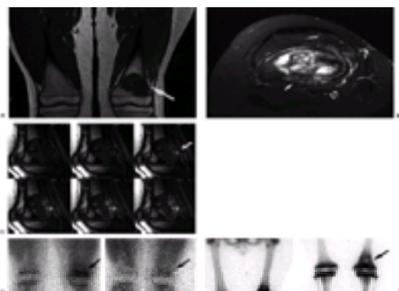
Osteogenic sarcoma in a 14-year-old boy evaluated by MR imaging and scintigraphy. A: Coronal T1-weighted image of the entire femur confirms a tumor with well-defined margins (*arrow*) and no skip metastases. The very low signal intensity area within the tumor corresponds to a cement plug after biopsy. B: Axial fat-suppressed, T2-weighted images show that the tumor extends posteriorly underneath the periosteum (*closed arrow*). The popliteal vessels (*open arrow*) are spared. C: Dynamic fast spoiled gradient echo images, obtained at 3-second intervals, show that the subperiosteal component of the lesion enhances rapidly (*arrow*), indicating persistence of active tumor in this region. This scan was performed after therapy. D: Thallium-201 scan before (*left*) and after (*right*) therapy shows that the intense radiotracer uptake in the tumor (*arrow*) in the initial study decreases markedly after therapy. E: Tc-99m methylene diphosphonate (MDP) scan after therapy shows that there is increased radiotracer uptake in the tumor (*arrow*). There is no evidence of skip metastasis, and the remainder of the study did not show metastatic disease.
